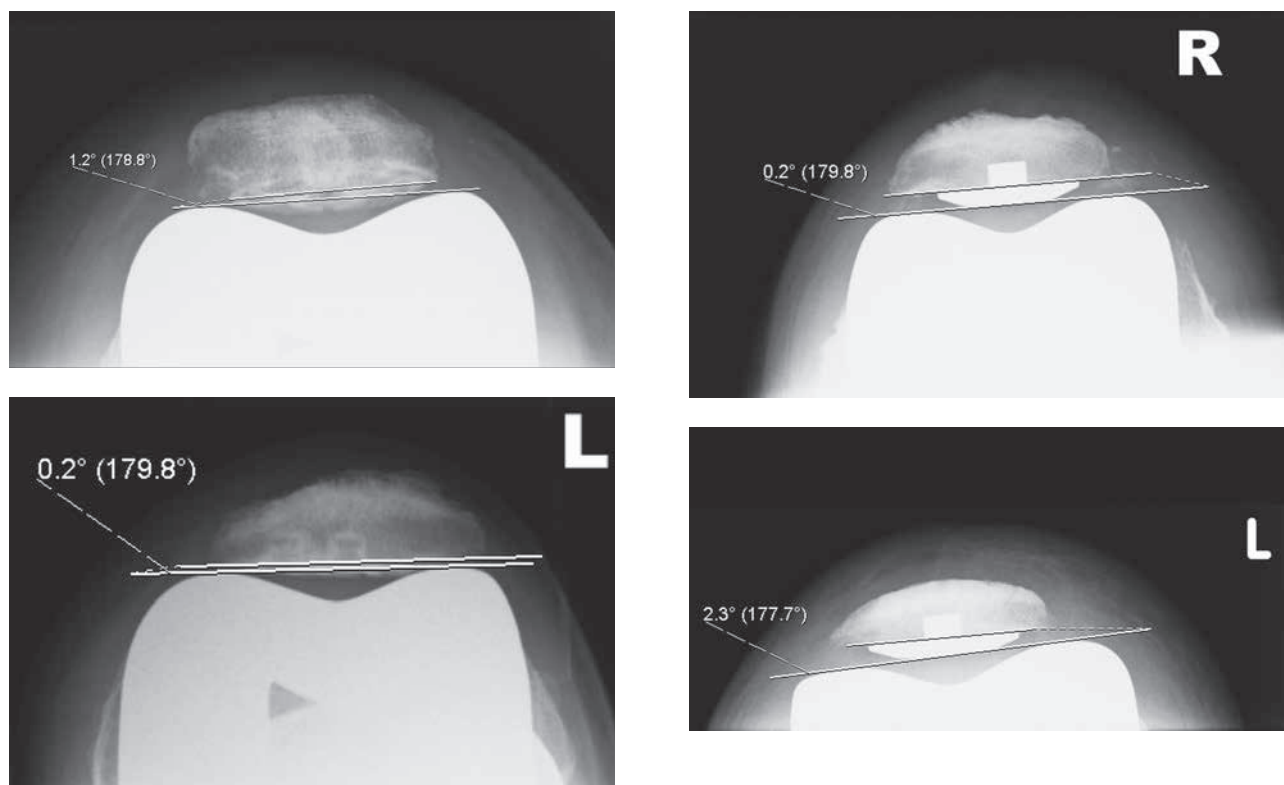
Series of radiographs demonstrating almost parallel patellar resection planes to the trochlea, with the use of the proposed method.
